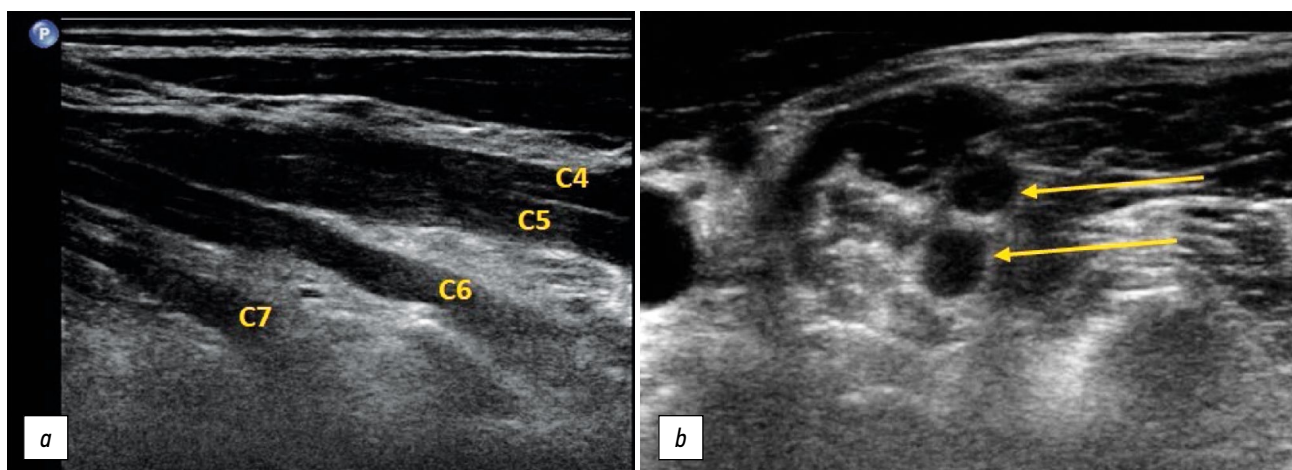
Ultrasound examination of Parsonage–Turner syndrome. Thickening of the ventral branches of the C5, C6, and C7 spinal nerves and the primary upper and middle trunks of the plexus (arrows). Longitudinal (*a*) and transverse (*b*) projections of the supraclavicular part of the brachial plexus.
